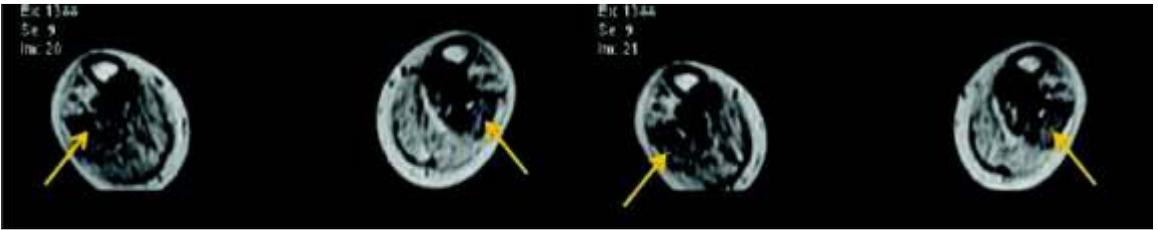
T1 weighted axial musculoskeletal MRI images of Peroneus Longus and Brevis 6 months after Autologous BMMNCs transplantation, arrows showing muscle regeneration and reduced fatty infiltration
